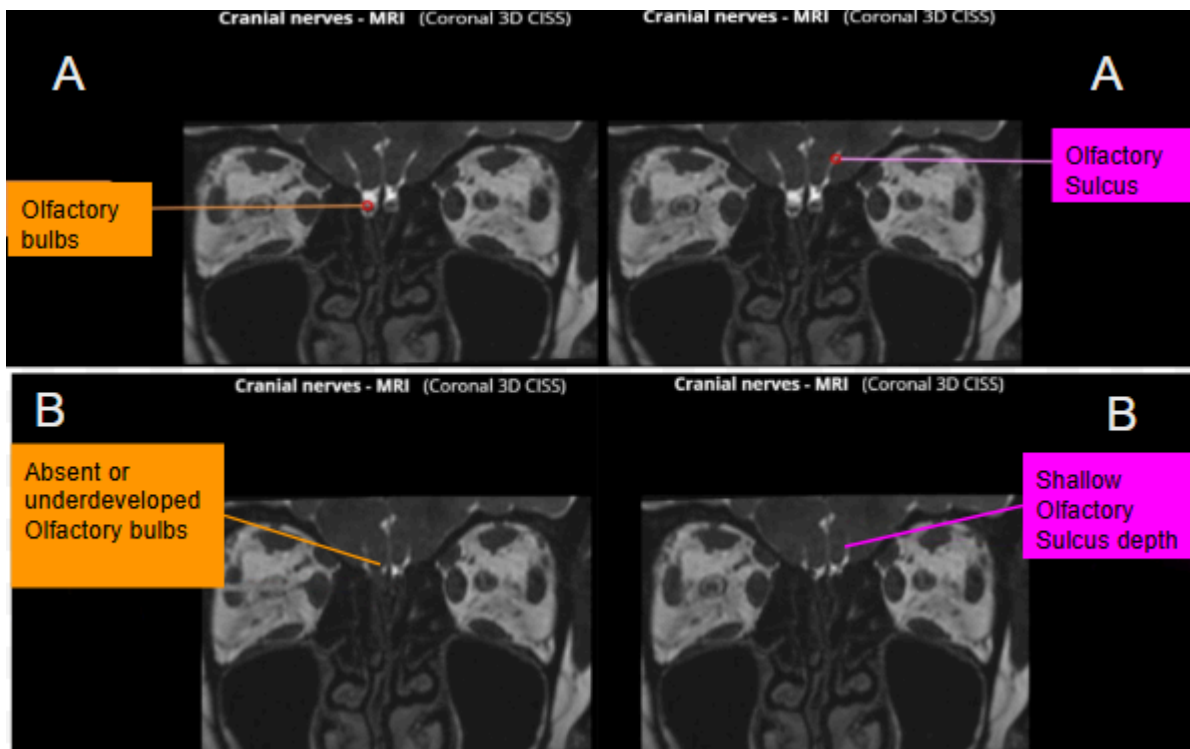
Coronal olfactory bulb and sulcus MRI image of a healthy female, where letter “A” represents normal olfactory ability and “B” represents Congenital Anosmia. Courtesy of IMAIOS © "Antoine MICHEAU, MD , Denis HOA, MD, e-Anatomy, published July 29th 2024, Imaging of cranial nerves and brainstem: normal 3D CISS MR of cerebral fossa, <https://doi.org/10.37019/e-anatomy/ed745028-c12f-405f-8d85-dbefa043aac3>”
